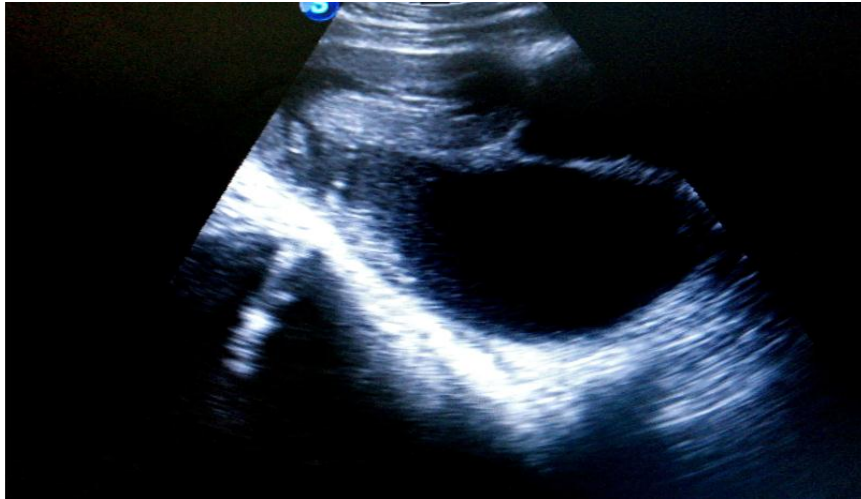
suprapubic ultrasound. Large hematocolpos retrovesical, prolonged by hematometry.
